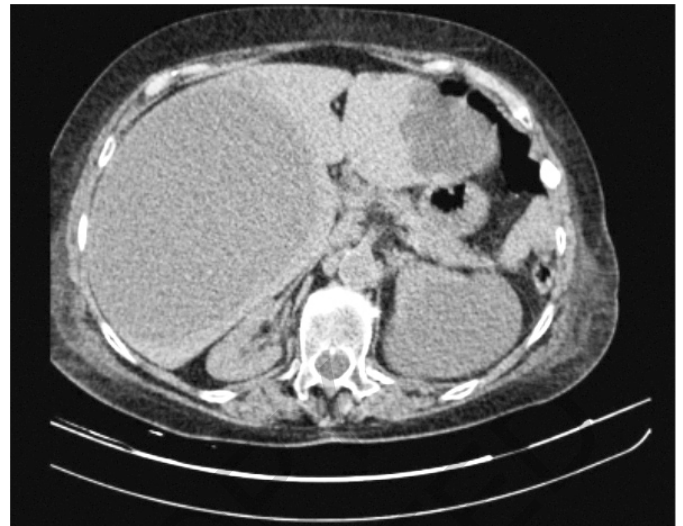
Abdomen CT scan case 1.
